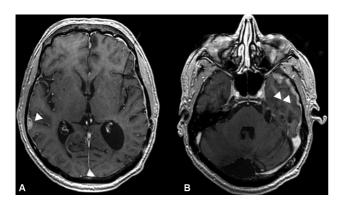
(A, B) Post-contrast T1-weighted images (5 months post-surgery) showing nodular pachymeningeal enhancement along the right temporal lobe, the left frontotemporal lobe, and the periorbital dura along the left temporal convexity (arrowheads).
